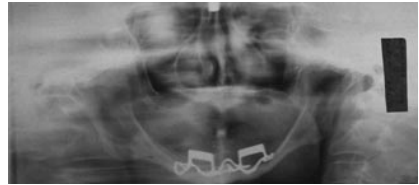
The panoramic X-ray of the old subperiosteal implant indicates some settling of the infrastructure into the mandibular canal.
